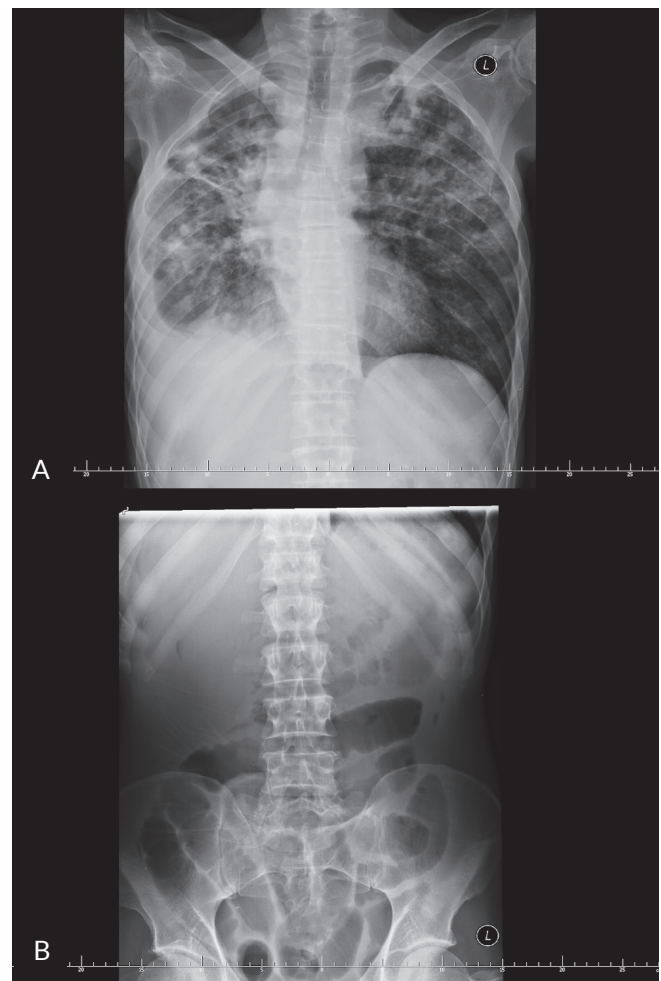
Plain chest (A) and abdominal (B) radiograph taken in the supine position on admission showing medium- and coarse patchy opacities, probably corresponding to post-specific changes, emphysematous clearings at the apices of both lungs, and a small amount of pleural fluid (A). Dilated bowel loops in the mid-abdomen and pelvis were also described (B)
